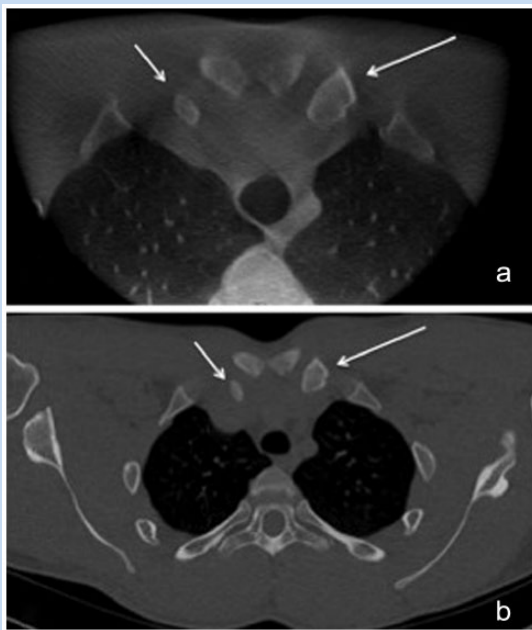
Intraoperative CT images. (a) Axial CT image showing reduction of the right medial clavicle (short white arrow) and relative symmetry with the left medial clavicle (long white arrow). (b) Axial CT image obtained 5 weeks following injury depicting unchanged position of the right sternoclavicular joint.
